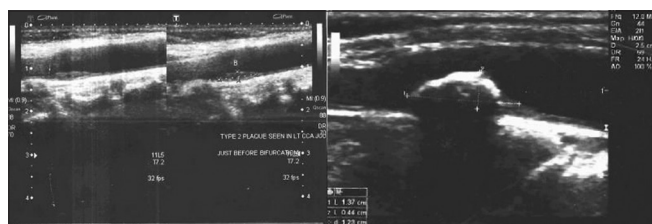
Carotid sonography showing type-2 plaque (echolucent) in left common carotid artery just before bifurcation and echogenic plaque at bifurcation in two different patients
